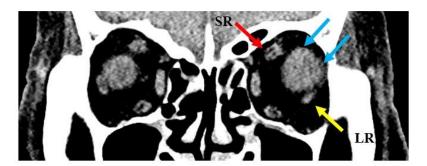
Coronal MRI showed the posterior portion of the elongated globe out from the muscle cone in the left eye (blue arrows) LR, lateral rectus muscle; SR, superior rectus muscle
